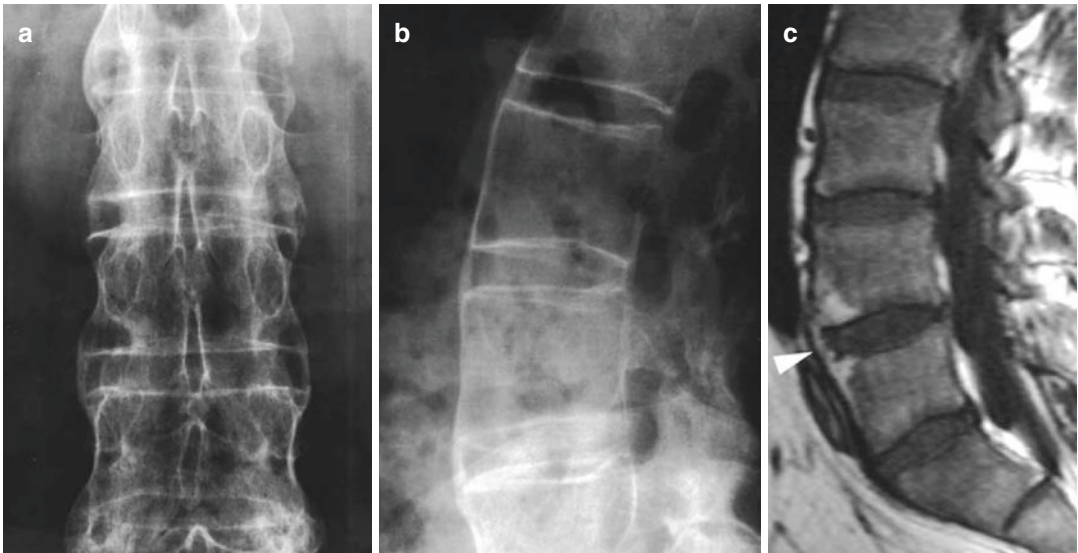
Syndesmophytes. Anterior-posterior (a) and lateral (b) radiographs reveal typical syndesmophytes. Sagittal T1-weighted spin echo MR image (c) shows high
